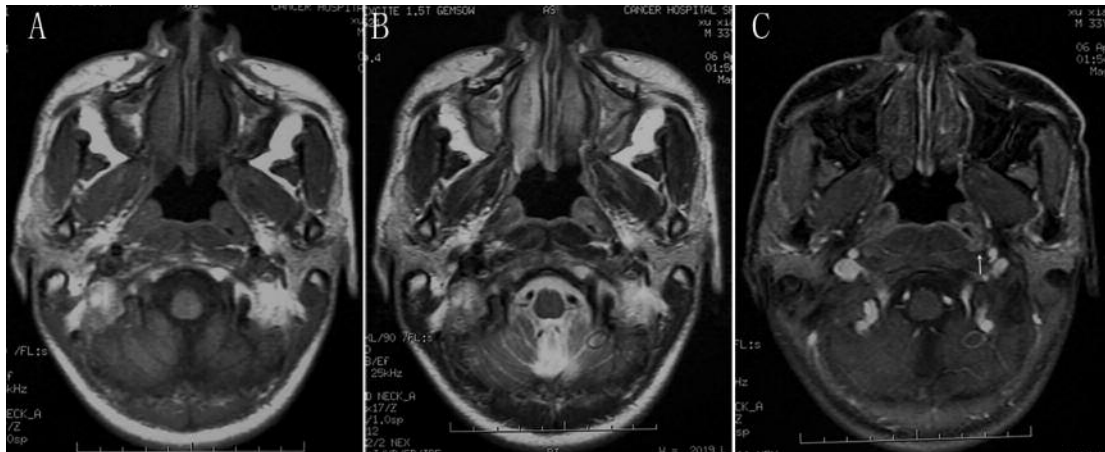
The tumour can be observed as abnormal enhancement (*C*, arrow) in the left Rosenmüller's recess with negative appearance in both T1- (*A*) and T2-weighted imaging (*B*).
